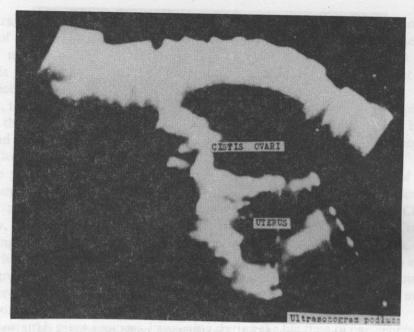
Longitudinal ultrasonogram of the woman with visible cistis ovari and uterus [14] (1966).
